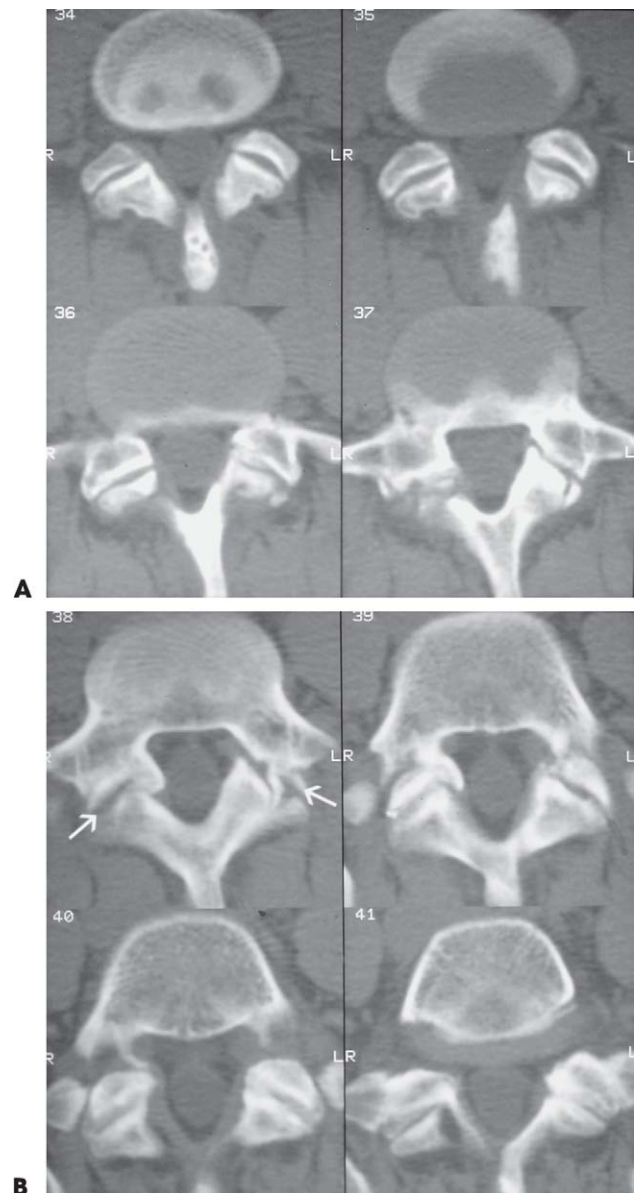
A and B. Axial CT bone window of L5. A and B represent progressively caudal slices. Note in all slices there is a lucency somewhat resembling an apophyseal joint. These lucencies represent bilateral spondylolytic defects (arrows).
